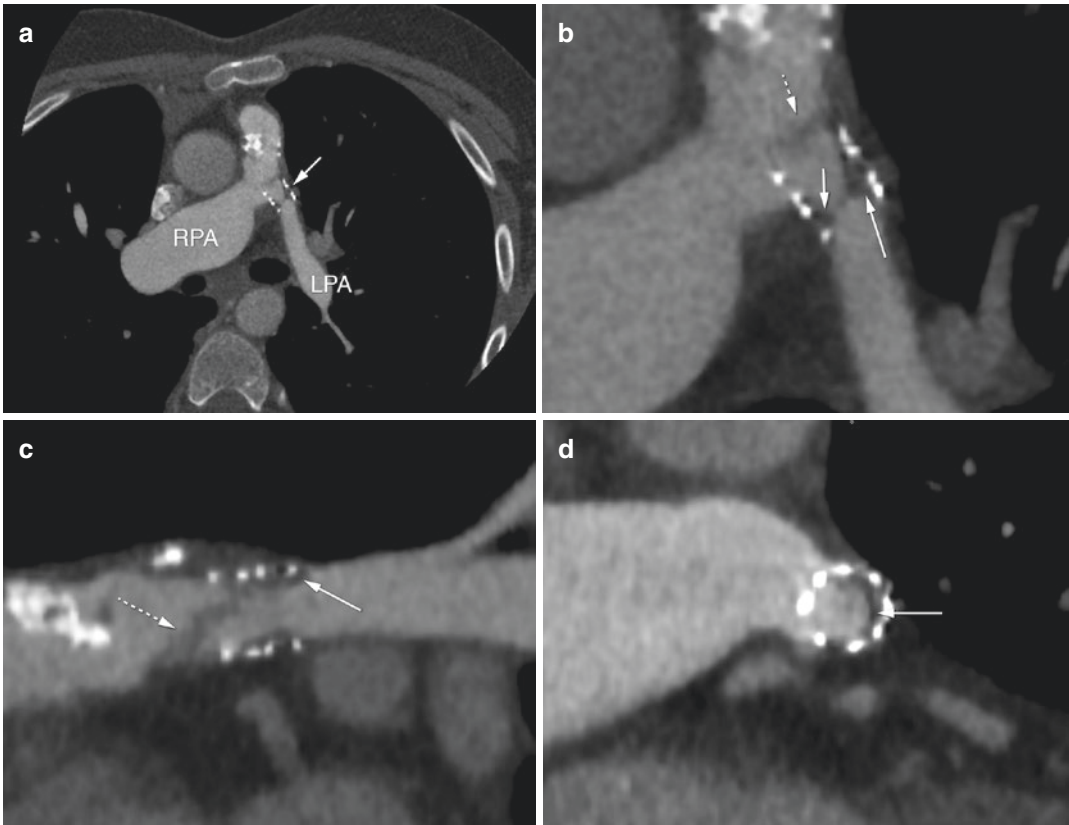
Stented left pulmonary artery. CT angiography in an 11-year-old male patient with tetralogy of Fallot with pulmonary atresia and major aortopulmonary collateral arteries, after unifocalisation of the collaterals, insertion of pulmonary valve homograft and stent in the proximal left pulmonary artery. (a) The axial reconstruction
